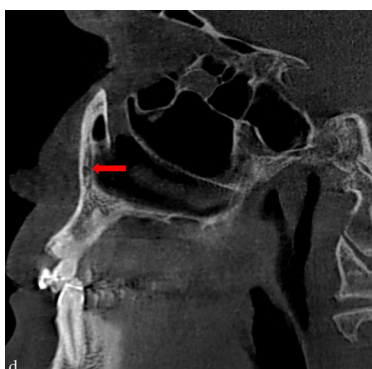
CBCT (cone-beam computed tomography) images of the CS (Canalis sinuosus) course; a-c) The axial plane, d) The sagittal plane, and e, f) The coronal plane. c, d, and f) CBCT images showing double trunk CS
